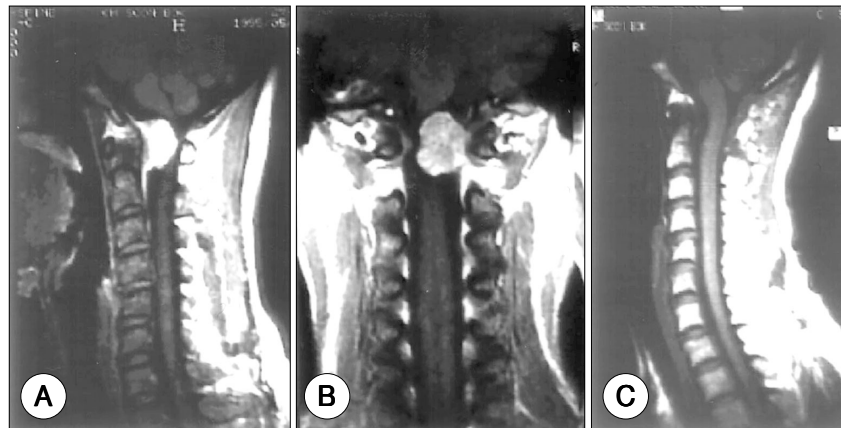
Magnetic resonance images in a meningioma patient. Preoperative image(A : sagittal, B : coronal) showing a round tumor mass in ventral portion of foramen magnum. Post-operative image(C) which taken 1 year later demonstrating complete removal of tumor mass
